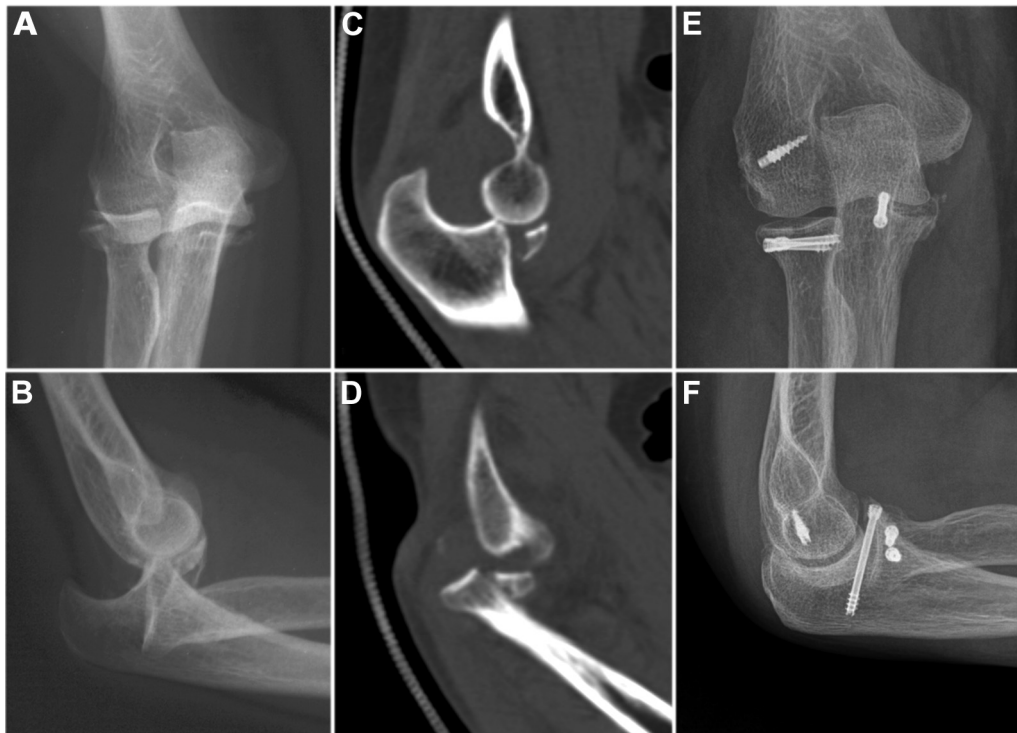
Open reduction and fixation for coronoid fracture in a posterolateral rotatory instability (PLRI) patient. (A, B) Anteroposterior and lateral views of preoperative radiographs of a 60-year-old woman showing posterior dislocation of the ulnohumeral joint with coronoid and radial head fractures of the right elbow. (C, D) The dislocated ulnohumeral joint was consistently apparent, although a closed reduction was attempted. (E, F) Anteroposterior and lateral views of the postoperative radiographs. An open reduction and fixation for coronoid fracture was performed through a medial approach, and open reduction and fixation of the radial head fracture and open repair of the lateral ulnar collateral ligament were achieved through a lateral approach.
